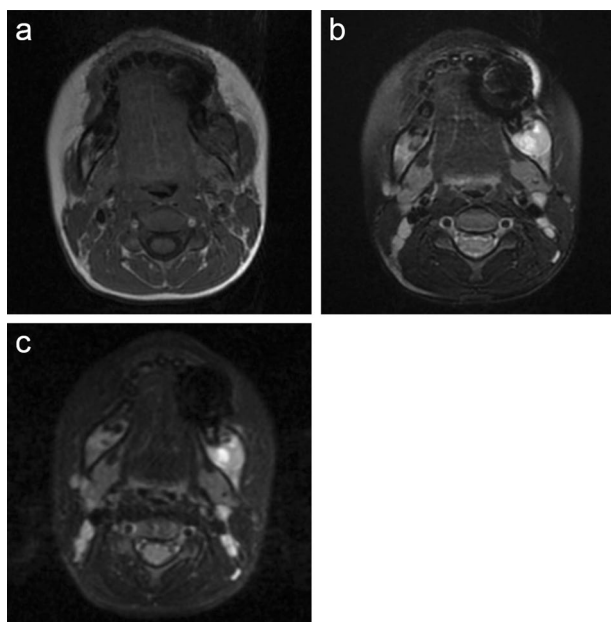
MR examination. a T1-weighted image shows the lesion isointense with muscle tissue. b T2-weighted images reveals an internal inhomogeneous high signal, with a portion of the lesion exhibiting an especially high signal. c T2 IDEAL water imaging shows an internal inhomogeneous high signal with a region of especially high signal
